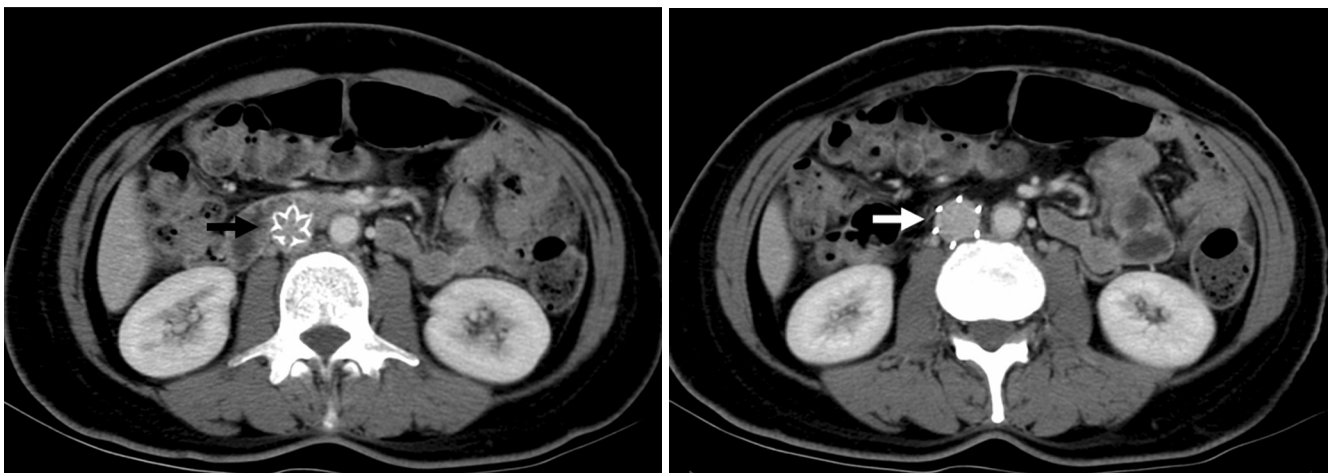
Abdominal CT demonstrates normal central placement of inferior vena cava filter without wall penetration or tilt (black and white arrow).
